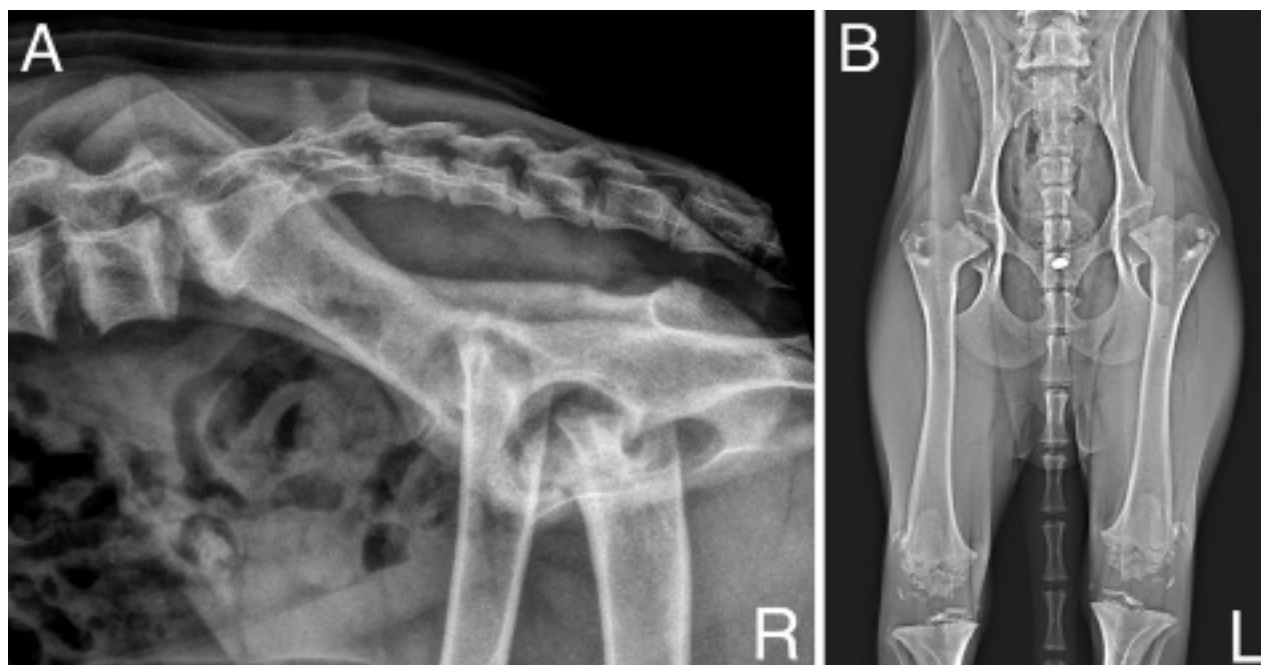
Right lateral (A) and ventrodorsal (B) radiographic images of the pelvis and hip joints of a 7-month-old 13-kg (28.6-lb) sexually intact male Hungarian Vizsla evaluated because of a history of exercise intolerance, stiff gait, and reluctance to play.
